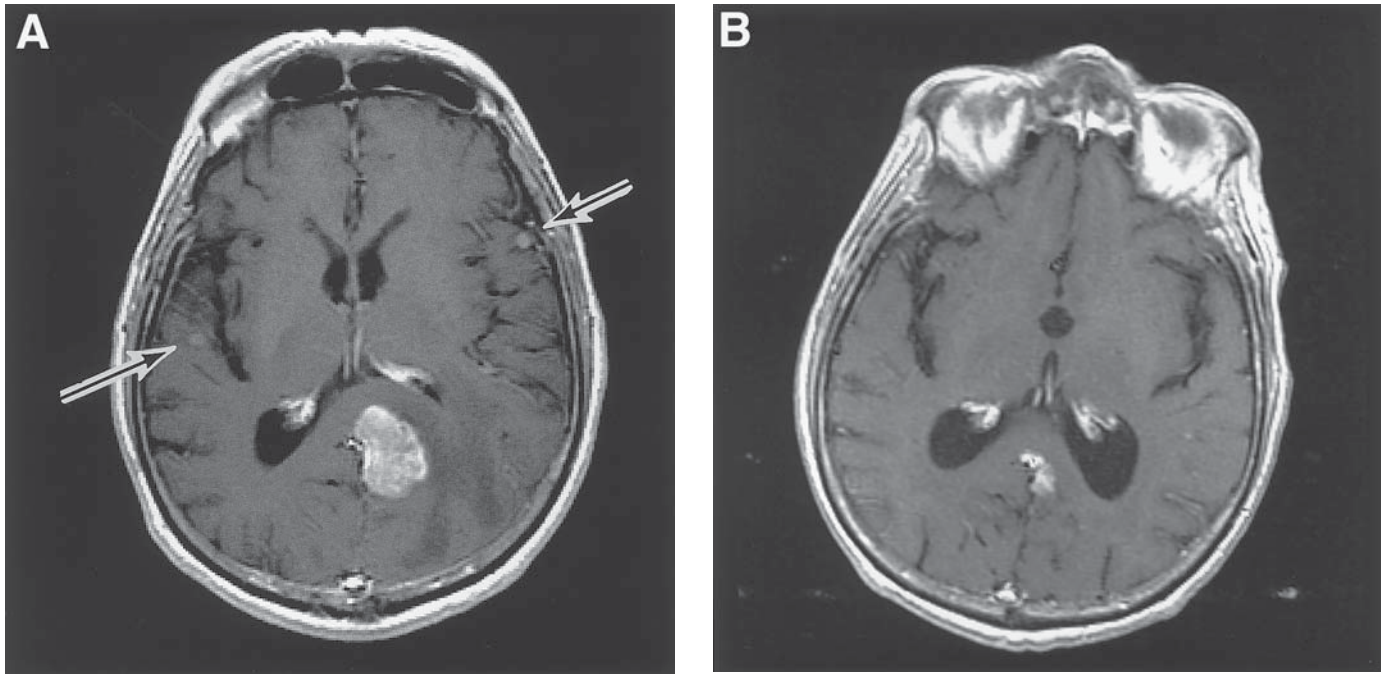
(A) Pre-WBRT. T1 weighted, postgadolinium MRI scan of a patient with breast cancer. A large left occipital enhancing metastatic lesion and smaller tumors in perisylvian areas on either side (arrows). (B) Post-WBRT. T1 weighted, postgadolinium MRI scan in the same patient 6 wk after 30 Gy WBRT. The perisylvian tumors have disappeared and occipital lesion is reduced in size.
